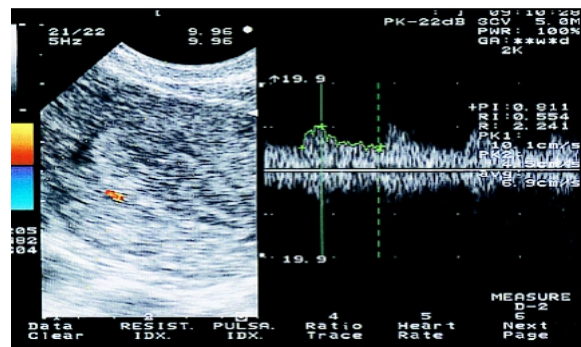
Blood Flow – Doppler of endometrium
